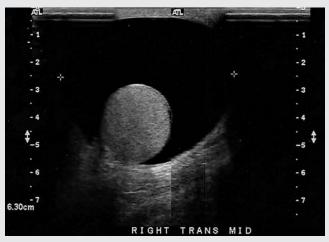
Transverse sonogram of the scrotum.
